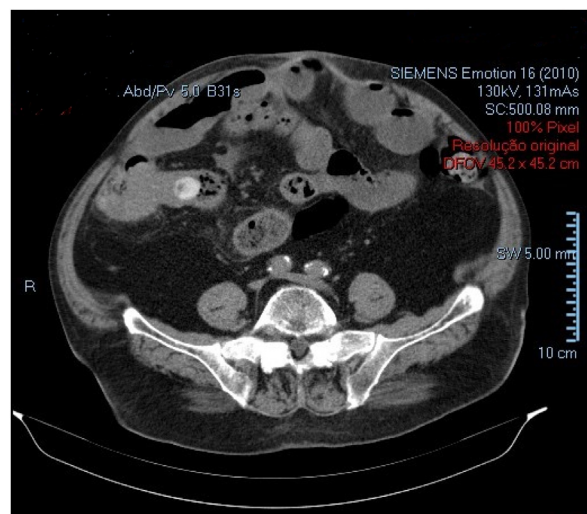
CT showing the hyperdense lesion at the ileocecal transition.
